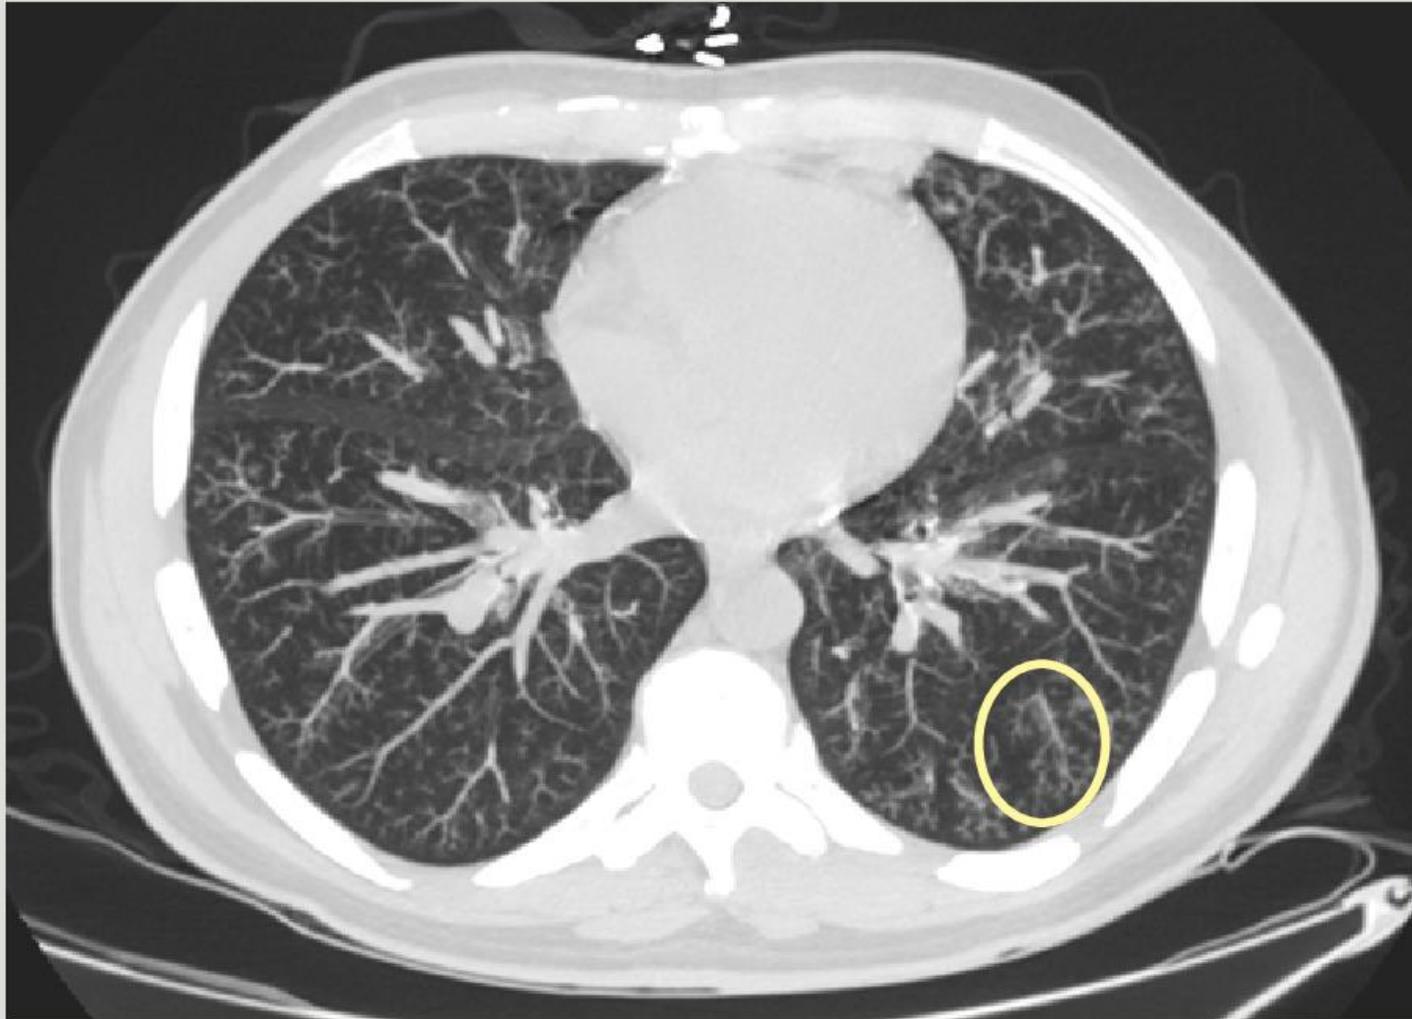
CT scan with tree-in-bud pattern
